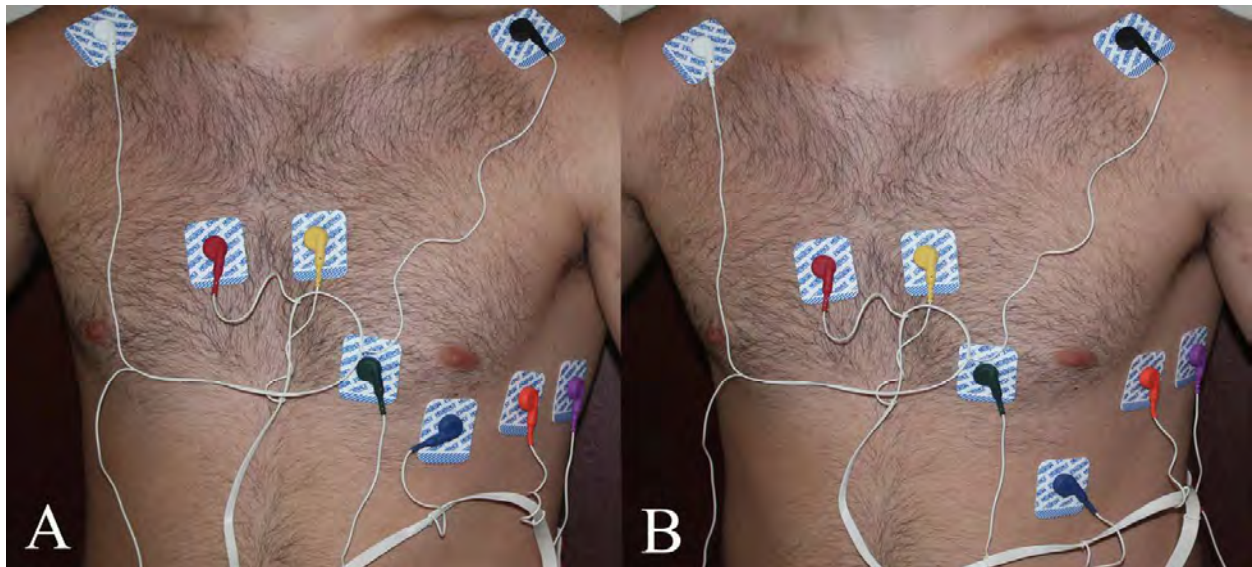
Placement of 12 lead electrodes for use with ultrasound imaging during exercise. A) normal configuration, B) adaptive configuration example.
